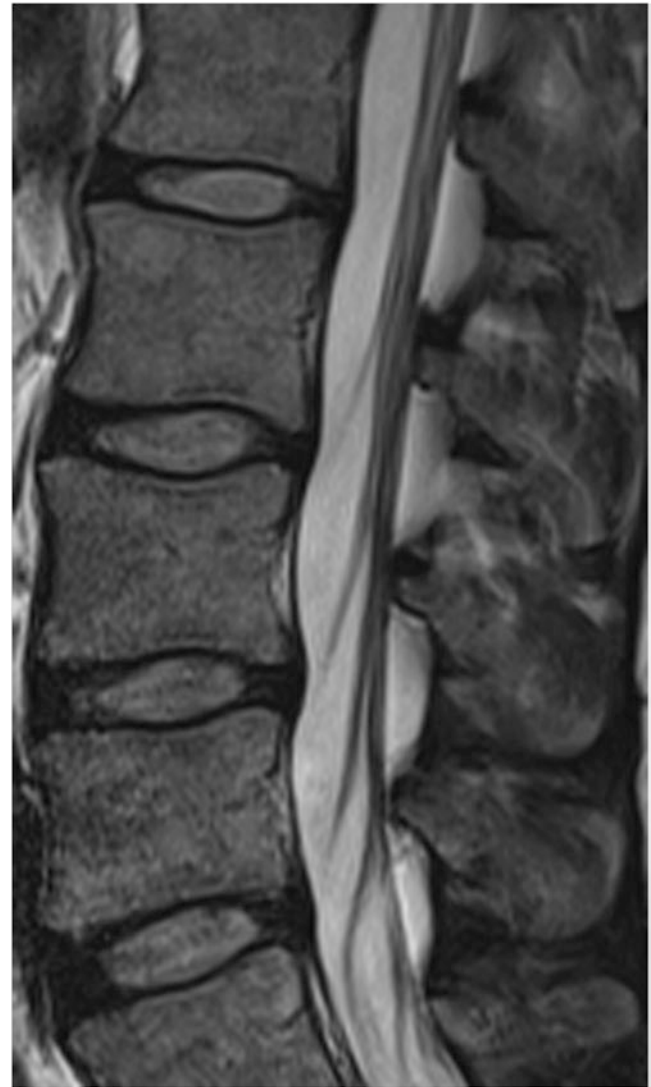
Magnetic resonance imaging of lumbar spine. Sagittal T2-weighted images revealing the typical “sawtooth” pattern of the posterior midline epidural fat (Acknowledgement of Dr. Alex Schabel)
